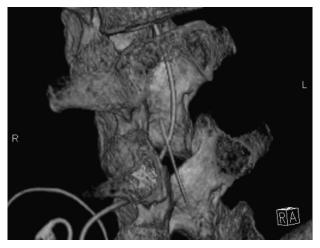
Lateral oblique view from reconstructed CT scan demonstrating functional intrathecal catheter and retained fragment.
